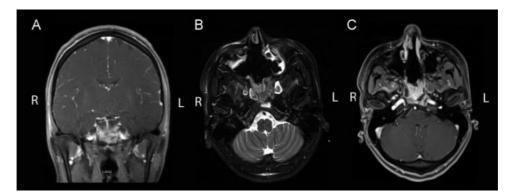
Enhanced magnetic resonance imaging coronal (A) and axial (C) disclosing recurrence of the clival mass. Solid enhancing component displacing the pituitary gland to the overlying optic chiasm. (B) Axial magnetic resonance imaging disclosing marked interval expansion of the mass. The cavernous sinuses are displaced laterally. The lesion lies adjacent to bilateral internal carotid arteries without apparent encasement.
